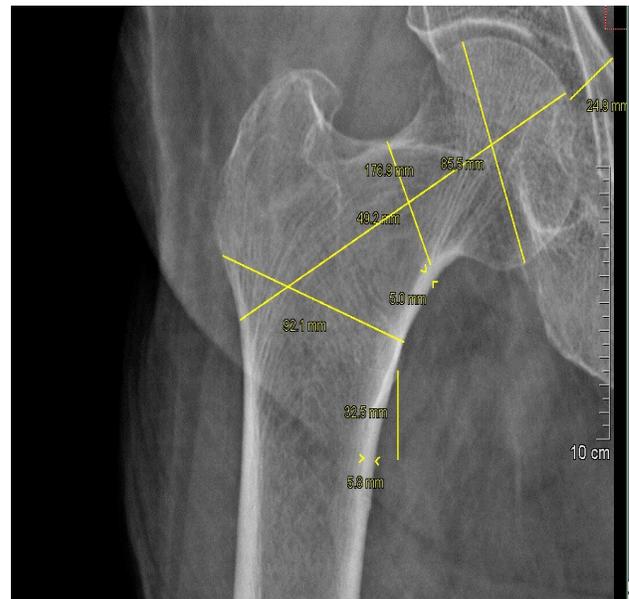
Hip geometrical measurements on a digital radiograph of osteopenia Post Menopausal Indian woman aged: 70, the measured Total hip BMD by the DXA in the same individual was: 0.762 g/ Cm 2
